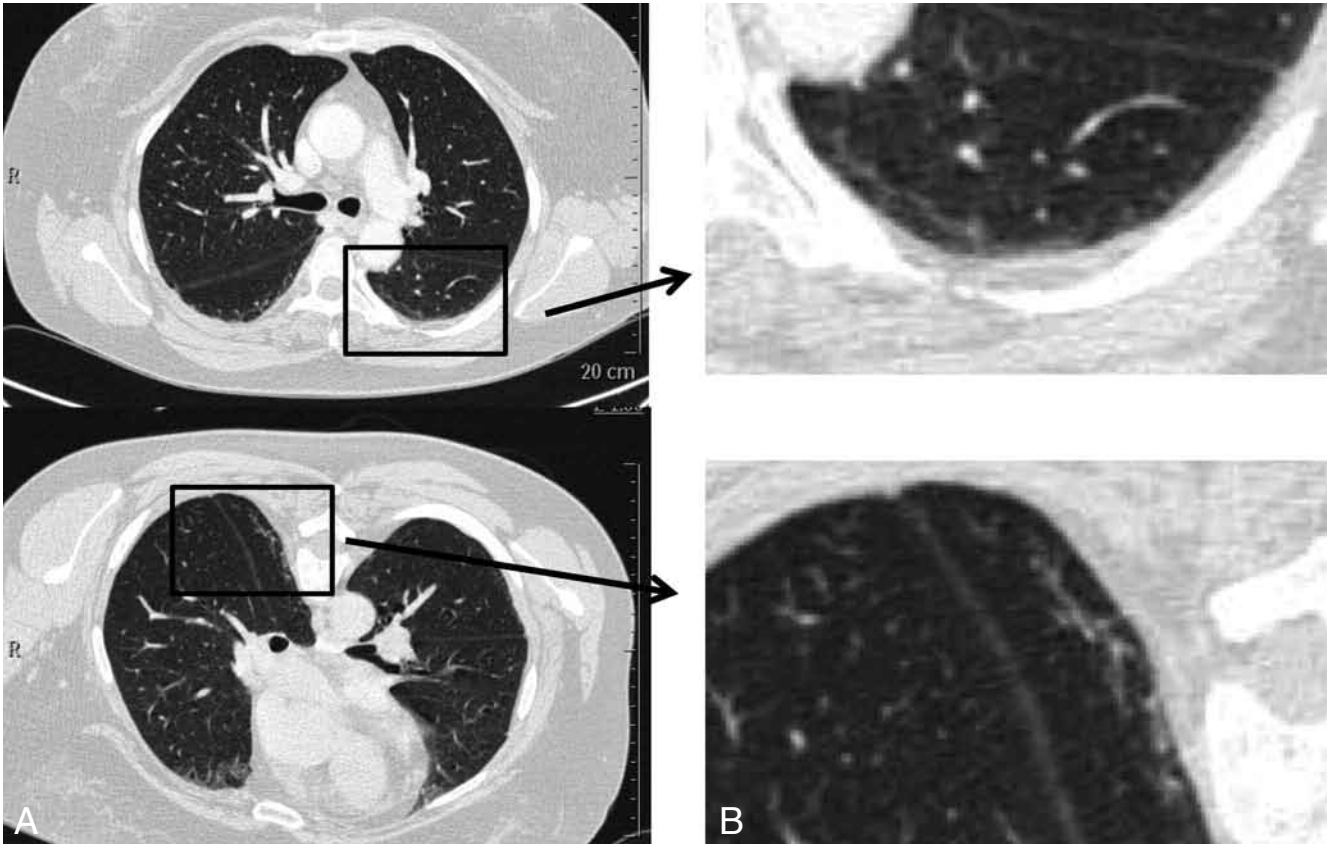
A. (supine position) B. (prone position) HRCT of the lung showed mild involvement of the lungs: thickening of the interlobular septa.
